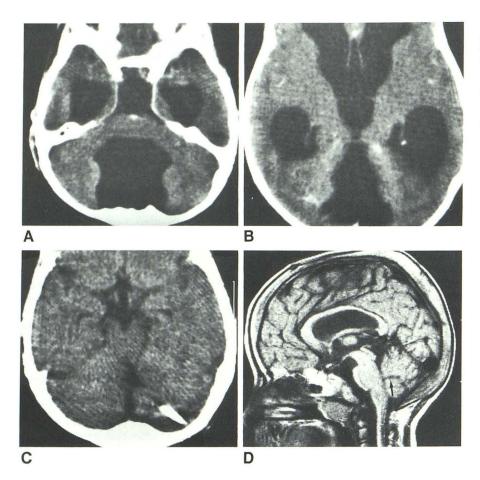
A and B, Axial CT scans show retrocerebellar fluid collection freely communicating with enlarged fourth ventricle. Note absence of a large part of vermis.
